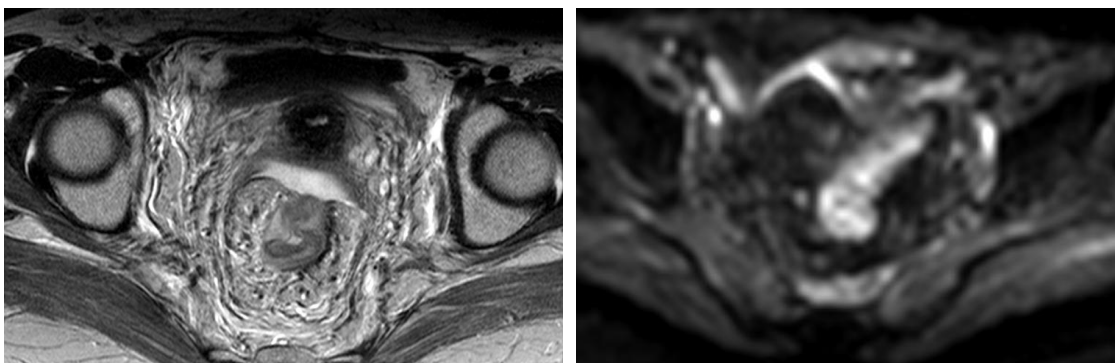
T2w MRI showing post RT related edema which can mimic disease in certain cases.
